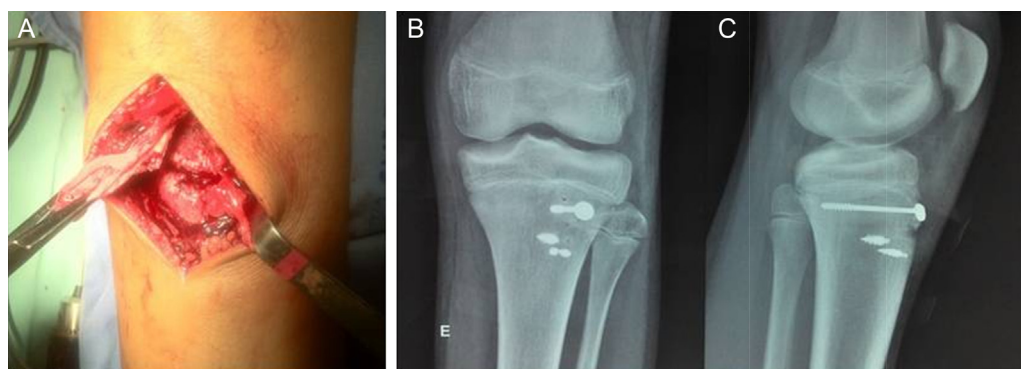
Intraoperative image (A) showing avulsed fragment of the ATT; postoperative control radiographies in anteroposterior (B) and lateral (C) view with fixation using screw and anchors.
